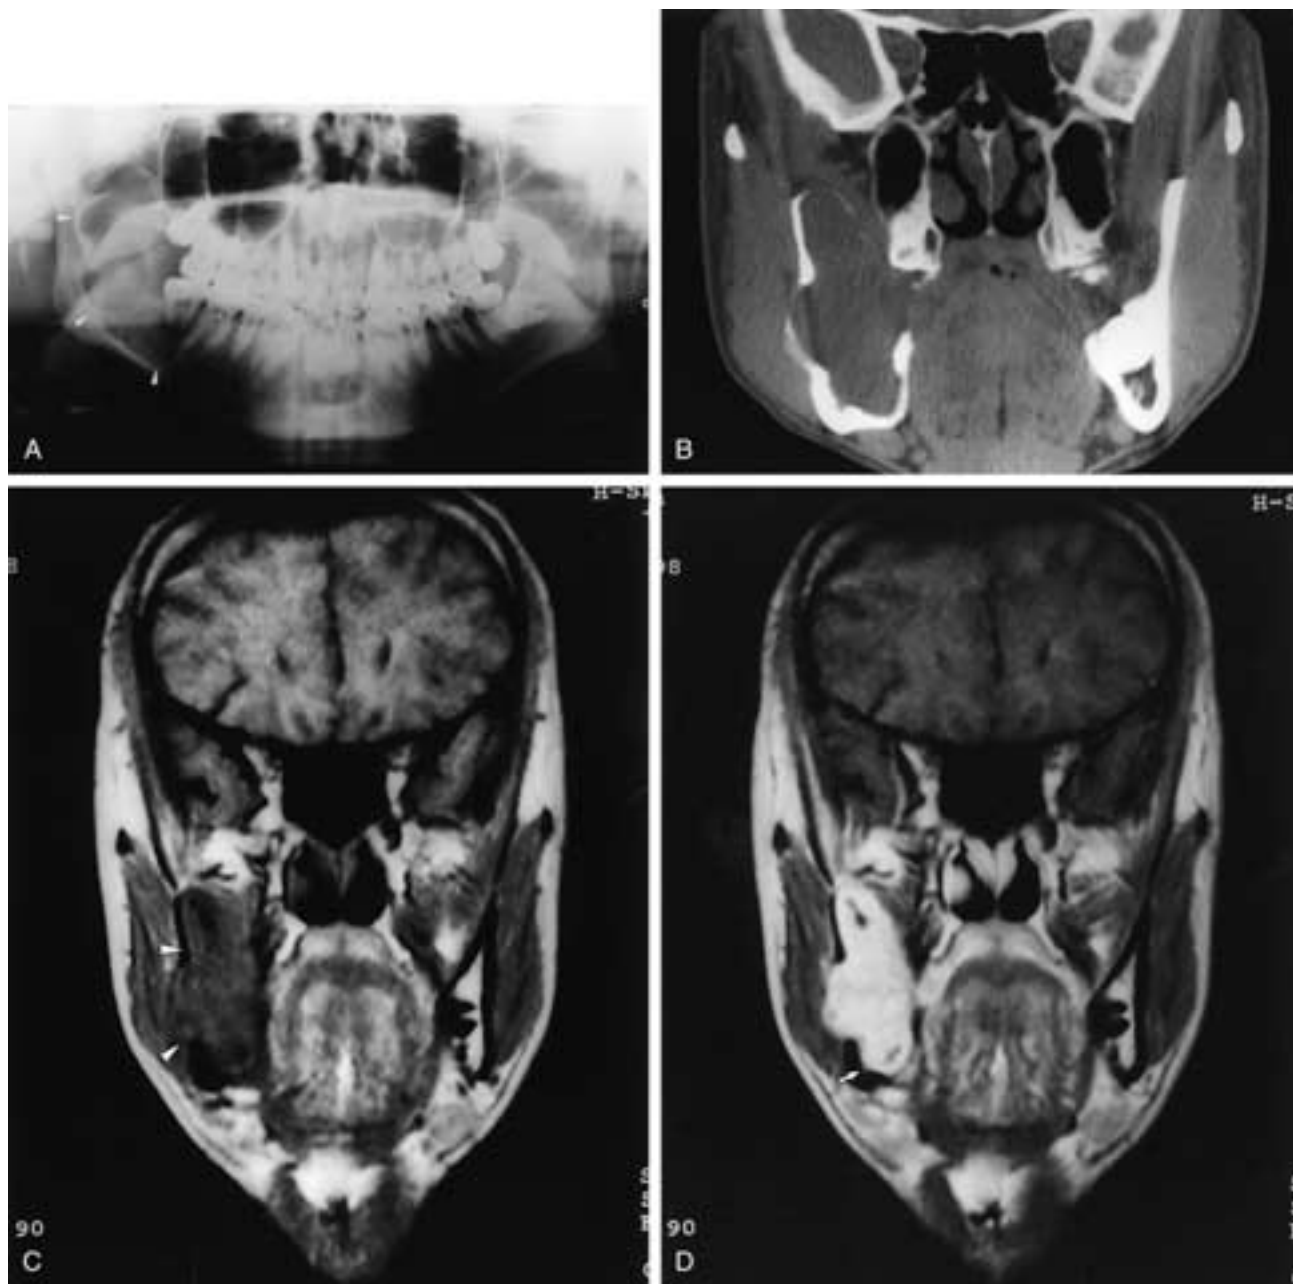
Multilocular ameloblastoma in a 25-year-old man. A, Pantomogram shows a large, multilocular, expansile lesion in the right side of the mandible (*arrowheads*). There is no root resorption of adjacent teeth. A cystic lesion is suspected. B, Coronal CT shows the expansile multilocular lesion, with bulging of the bony cortex without perforation. C, Coronal T1-weighted MR image reveals a lesion of homogeneously low signal intensity in the mandible (*arrowheads*). D, Enhanced coronal MR image shows the markedly enhanced solid lesion in the mandible. The mandibular canal can be seen under the solid mass (*arrow*).
